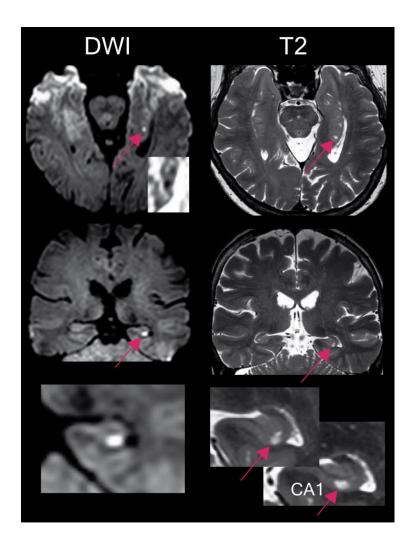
(A) MRI showing the hippocampal CA1 lesion in diffusion- and T2-weighted images in different planes. Red arrows indicate the lesion. Right lower inset indicates that the CA1 lesion extended over two slices (slice thickness 2 mm). Inset upper right shows the corresponding ADC map of the DWI lesion documenting the decrease of the ADC value.
